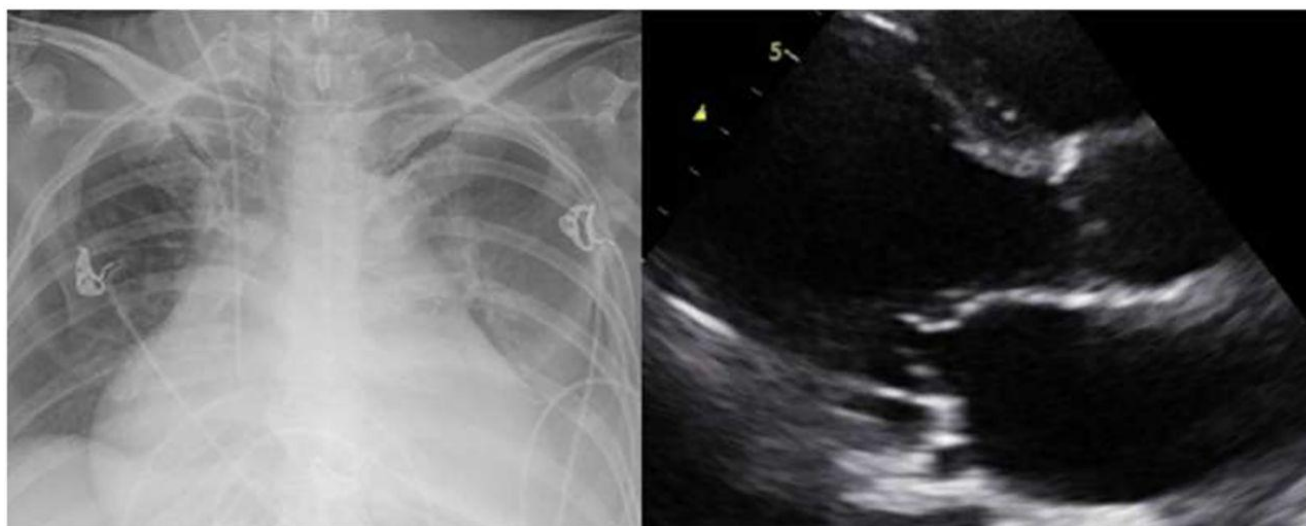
Chest X-ray showed cardiomegaly. Echocardiogram showed severe left ventricular dysfunction (LVEF 30%), bi-atrial dilatation, LV dilated, moderate MR and TR
